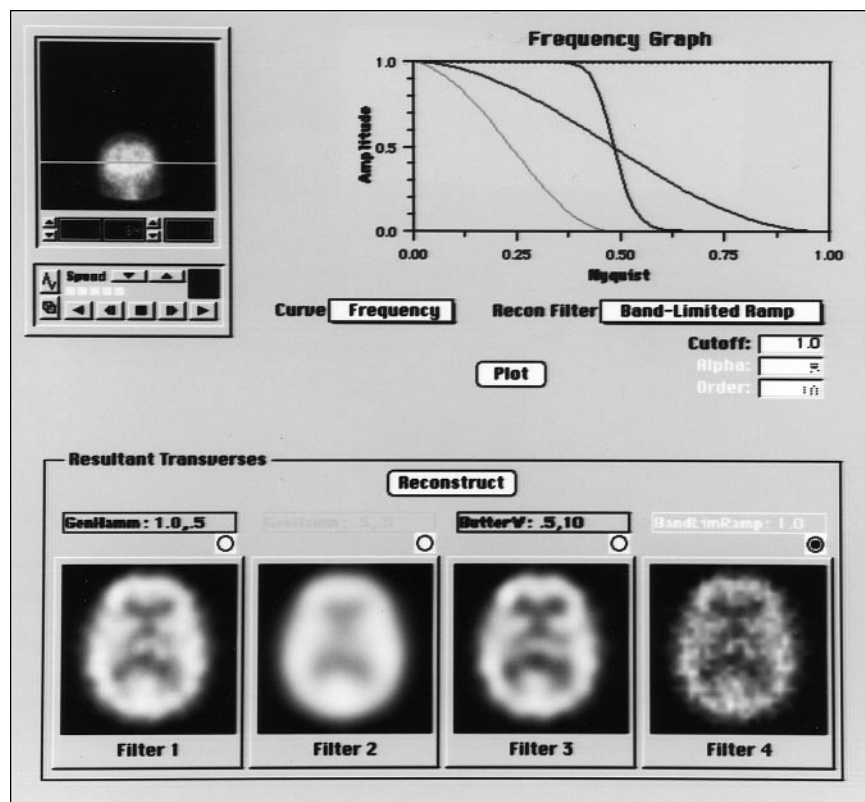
The effect of the choice of reconstruction filter on image noise/resolution. The 3 filters applied were (upper right): 1.0 Nyquist, 0.5 a Generalized Hamming (medium gray), 0.5 Nyquist, 0.5 a Generalized Hamming (light gray), and 0.5 Nyquist, 10th order Butterworth (dark gray). The corresponding reconstructions of a central slice from a 64×64 ^{99m}Tc -HMPAO brain SPECT study (bottom, left to right) demonstrate the superiority of the Butterworth filter (much better resolution than the 0.5 Nyquist Hamming, yet both better resolution and less noise than the 1.0 Nyquist Hamming).
